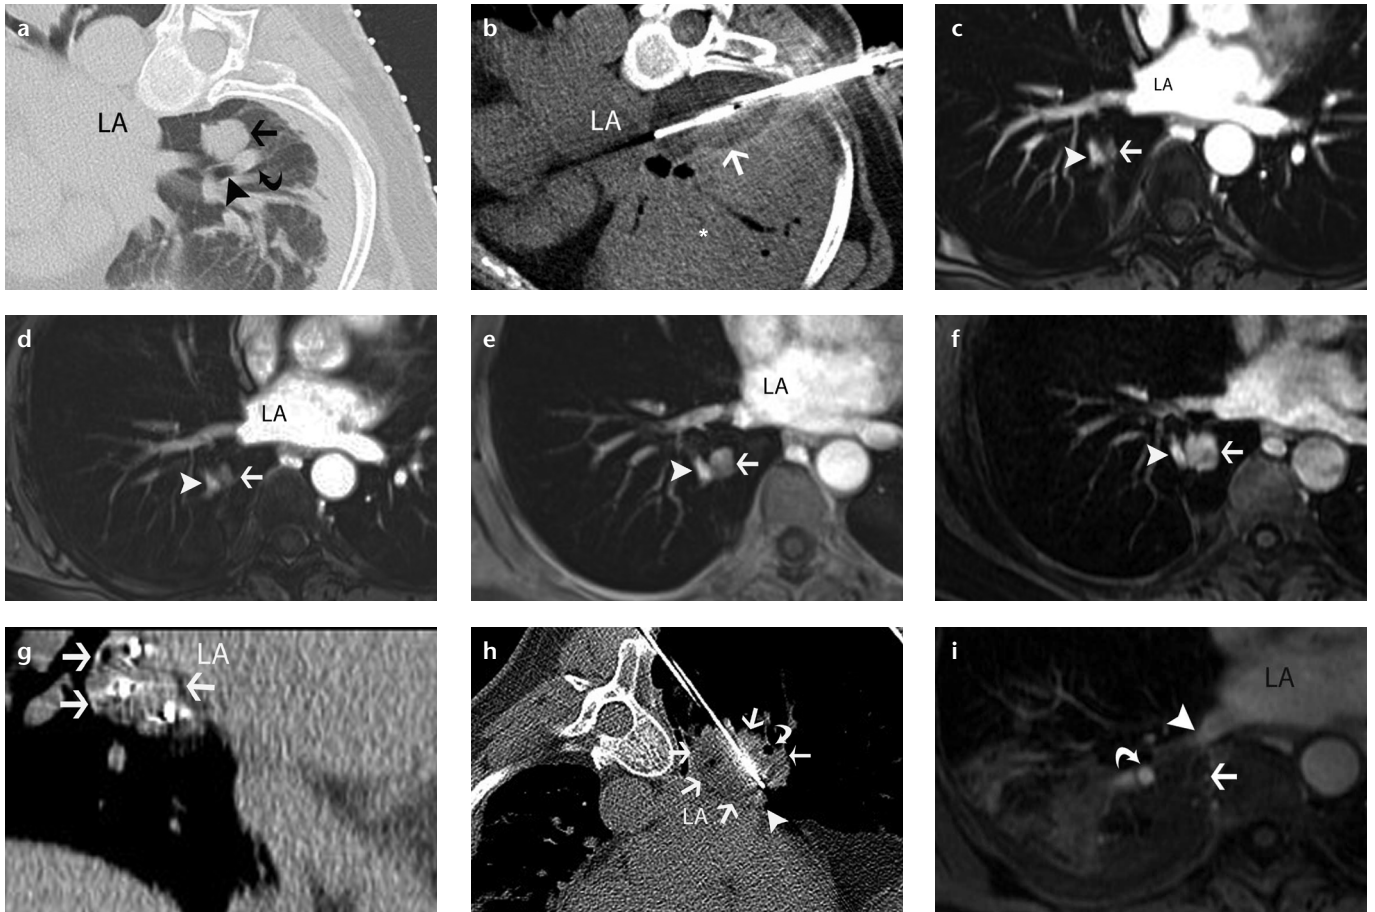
a–i. A 60-year-old woman with metastatic salivary gland adenoid cystic carcinoma to the lung treated by CT-guided percutaneous cryoablation. Axial CT scan (a) obtained during cryoablation of the right lower lobe pulmonary metastatic nodule (arrow). Note the adjacent lower lobe bronchus (arrowhead) and pulmonary artery (curved arrow). Axial CT scan (b) obtained during second freeze shows that the ice ball encompasses the nodule, involves the adjacent bronchus and pulmonary artery, and abuts the vertebra and the left atrium (LA). Note extensive peritumoral lung opacification (asterisk). Axial fat-suppressed contrast-enhanced T1-weighted GRE MR images of the chest obtained at three (c), six (d), 12 (e), and 18 months (f) show gradual growth of an enhancing soft tissue nodule (arrow) at the ablation site adjacent to the lower lobe pulmonary artery (arrowhead) consistent with a recurrence, which was treated percutaneously with another session of CT-guided cryoablation. Coronal reformation of CT scan (g) obtained following cryoablation applicator placement show peripheral location of three applicators within the tumor (arrows) in the shape of a triangle. Axial CT scan (h) obtained during freezing shows a low-attenuation ice ball (arrows) which covers the tumor and abuts the LA, pulmonary vein (arrowhead) and pulmonary artery (thin arrow) but involves the adjacent lower lobe bronchus (curved arrow). Axial fat-suppressed contrast-enhanced T1-weighted GRE MR image (i) of the chest obtained 24 hours after the cryoablation demonstrates unenhanced ablation zone (arrow) and a patent pulmonary artery (curved arrow) and vein (arrowhead).
